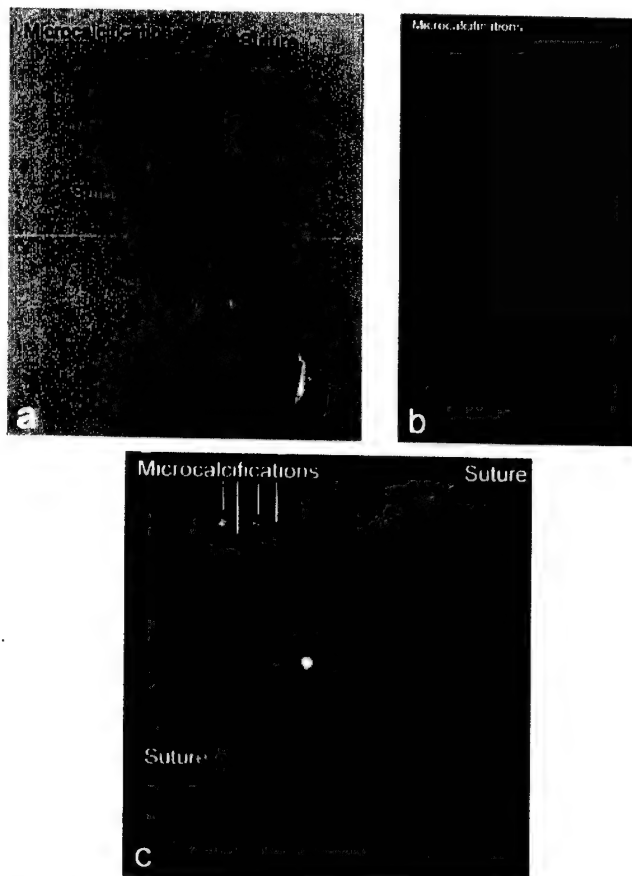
(a) Photograph of the breast tissue sample. Micro-calcifications are located at the top left corner of the sample (indicated by the arrow). Two sutures are knotted on the tissue as indicators. (b) Tissue x-ray mammogram of the tissue sample. This sample includes four small micro-calcifications at the top left corner. The brightness of the image has been reduced to make the micro-calcifications stand out from the high density tissue at the top left corner of the sample. As a result, most of the tissue is not visible in the x-ray image, except for the calcified region and some bright irregular regions (containing no calcification) at the center. (c) Vibro-acoustic image of the sample in (a) and (b). This image clearly shows four micro-calcifications as bright spots at the top left corner of the tissue sample. The two sutures are also indicated in the image. The location of micro-calcifications shown here matches well with those shown in the x-ray mammogram.
